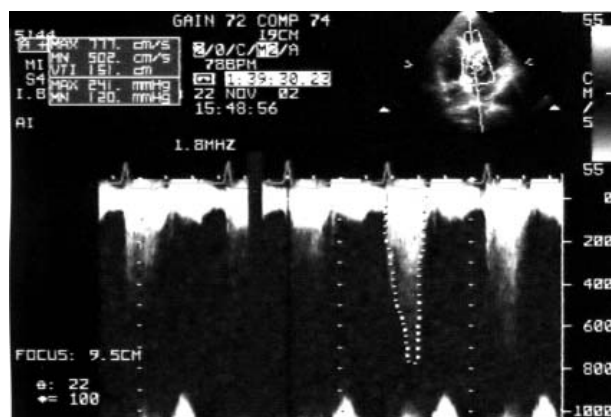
Echocardiography - LV/Ao gradient (quantitative Doppler).
